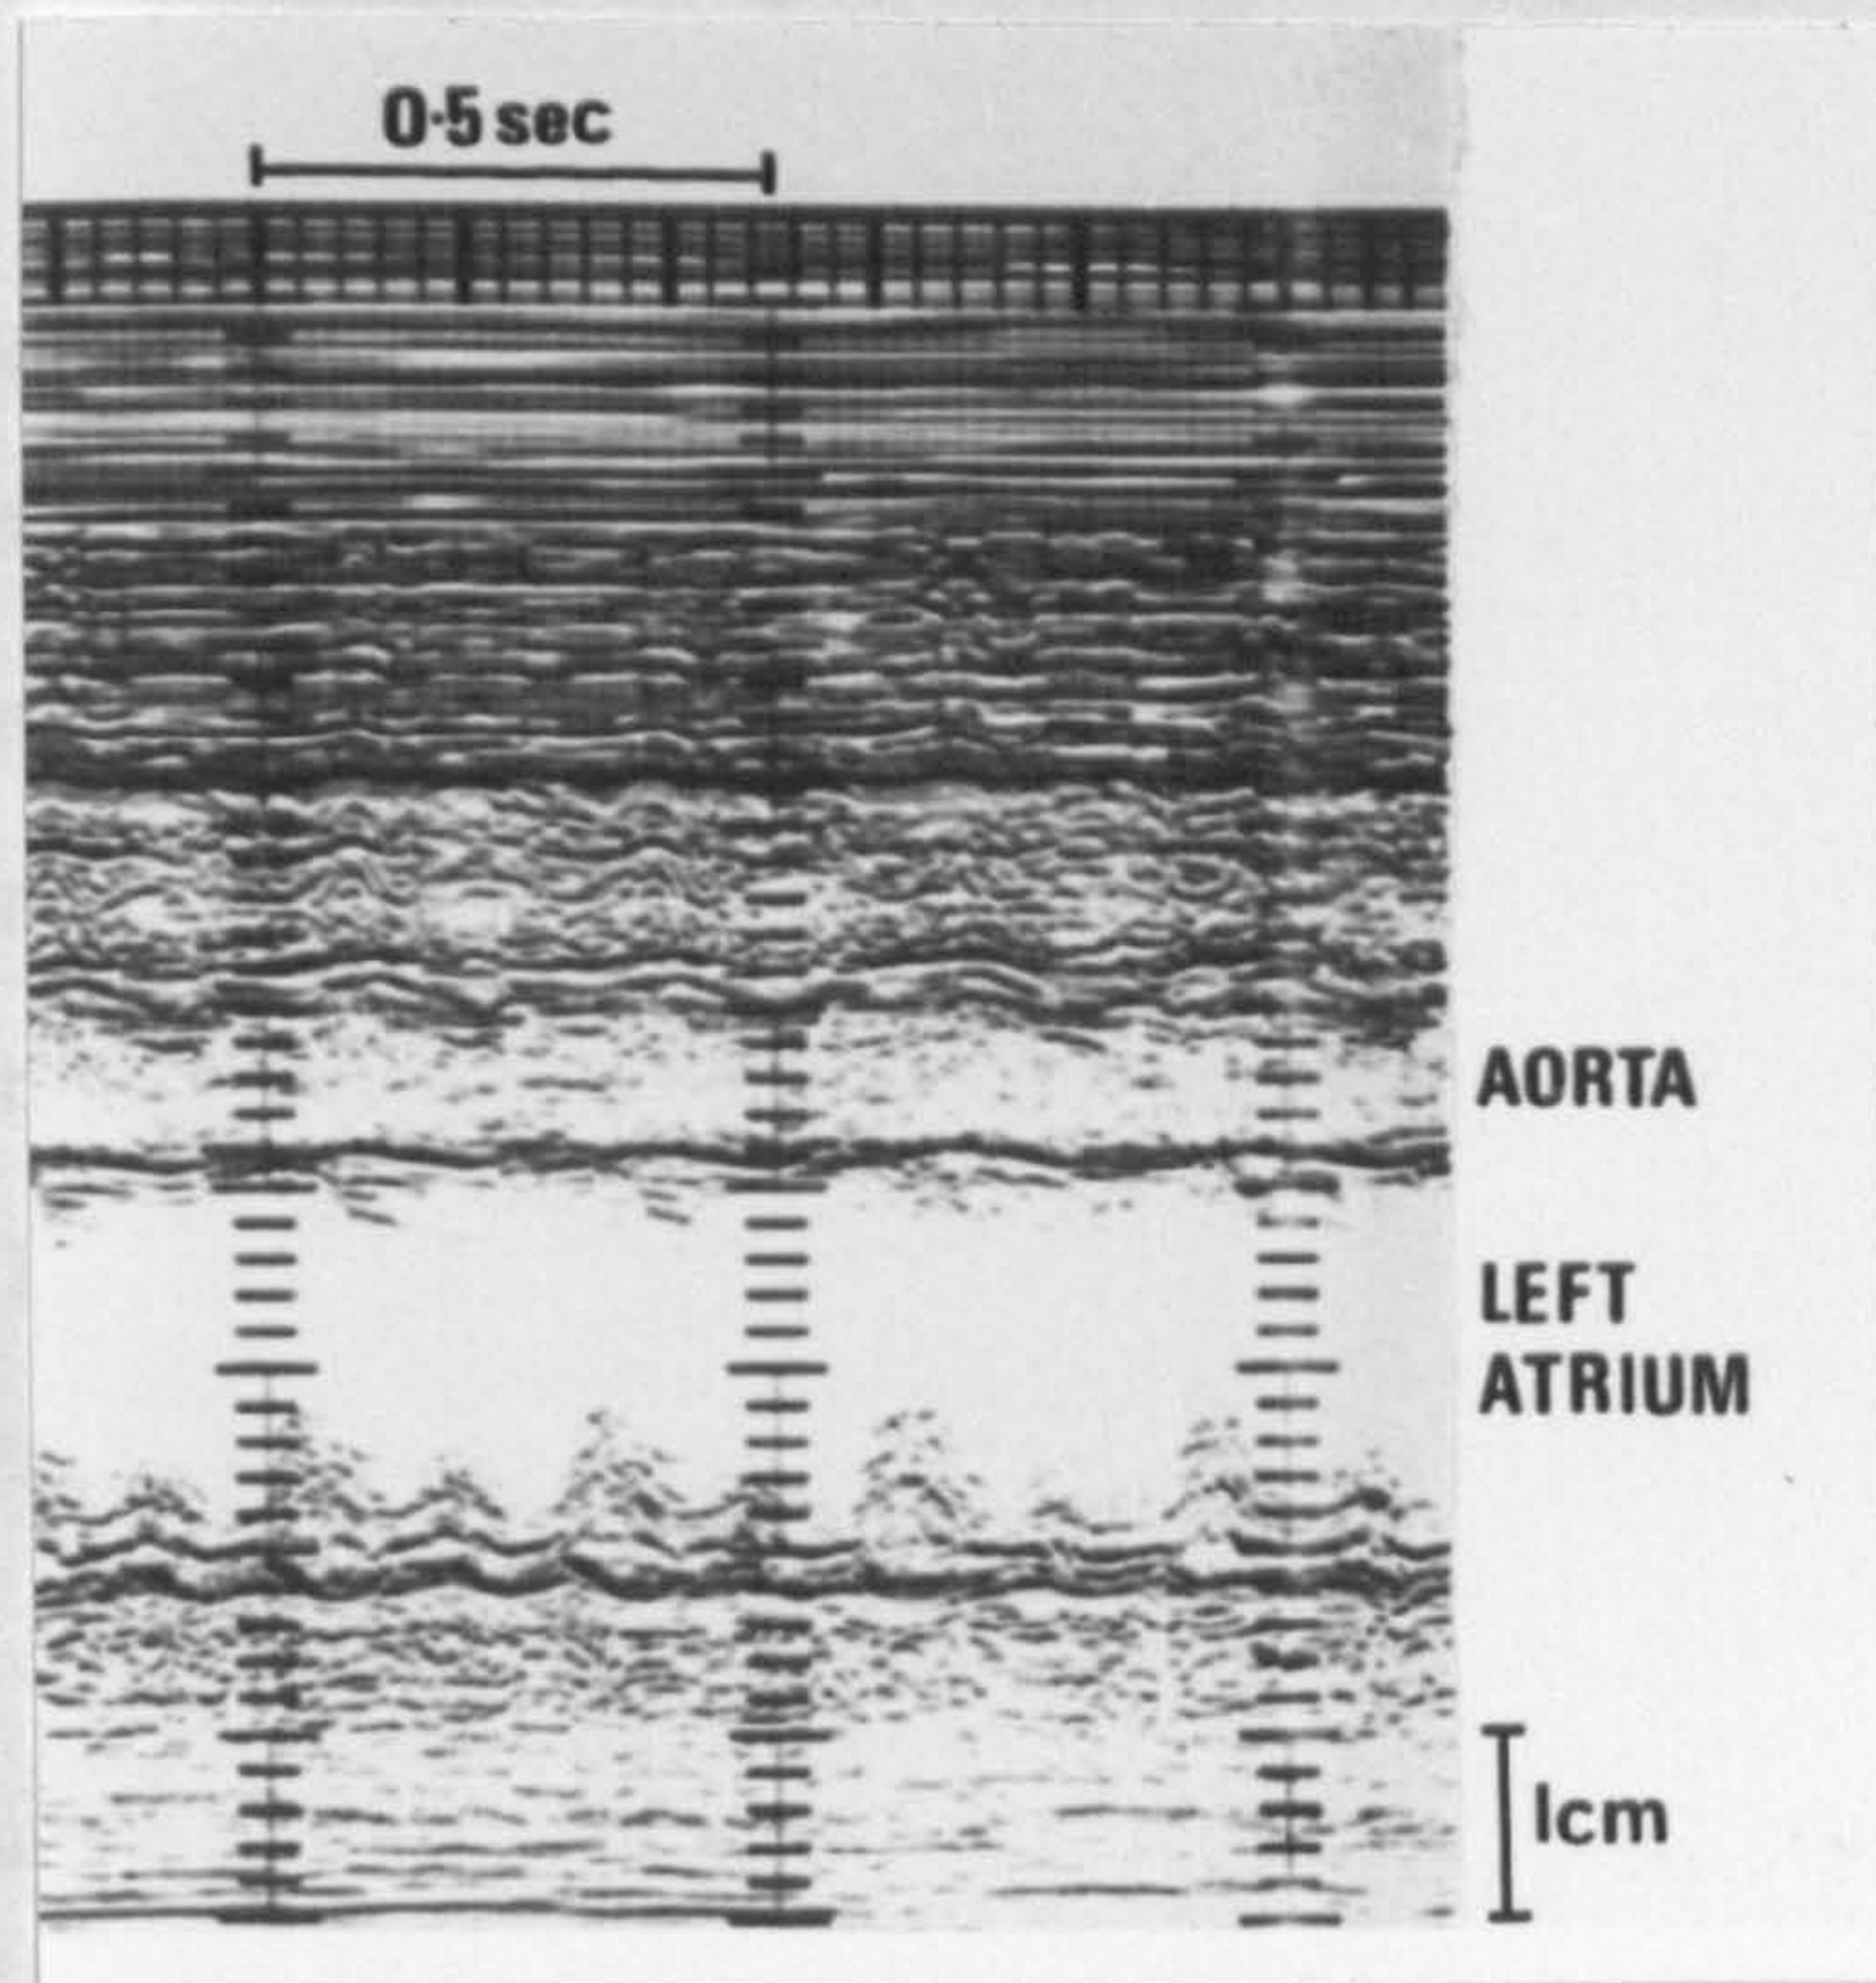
(a) Case 6. M mode echocardiogram across aorta and left atrium. Study of left atrial wall motion shows an atrial rate of 400/min.
